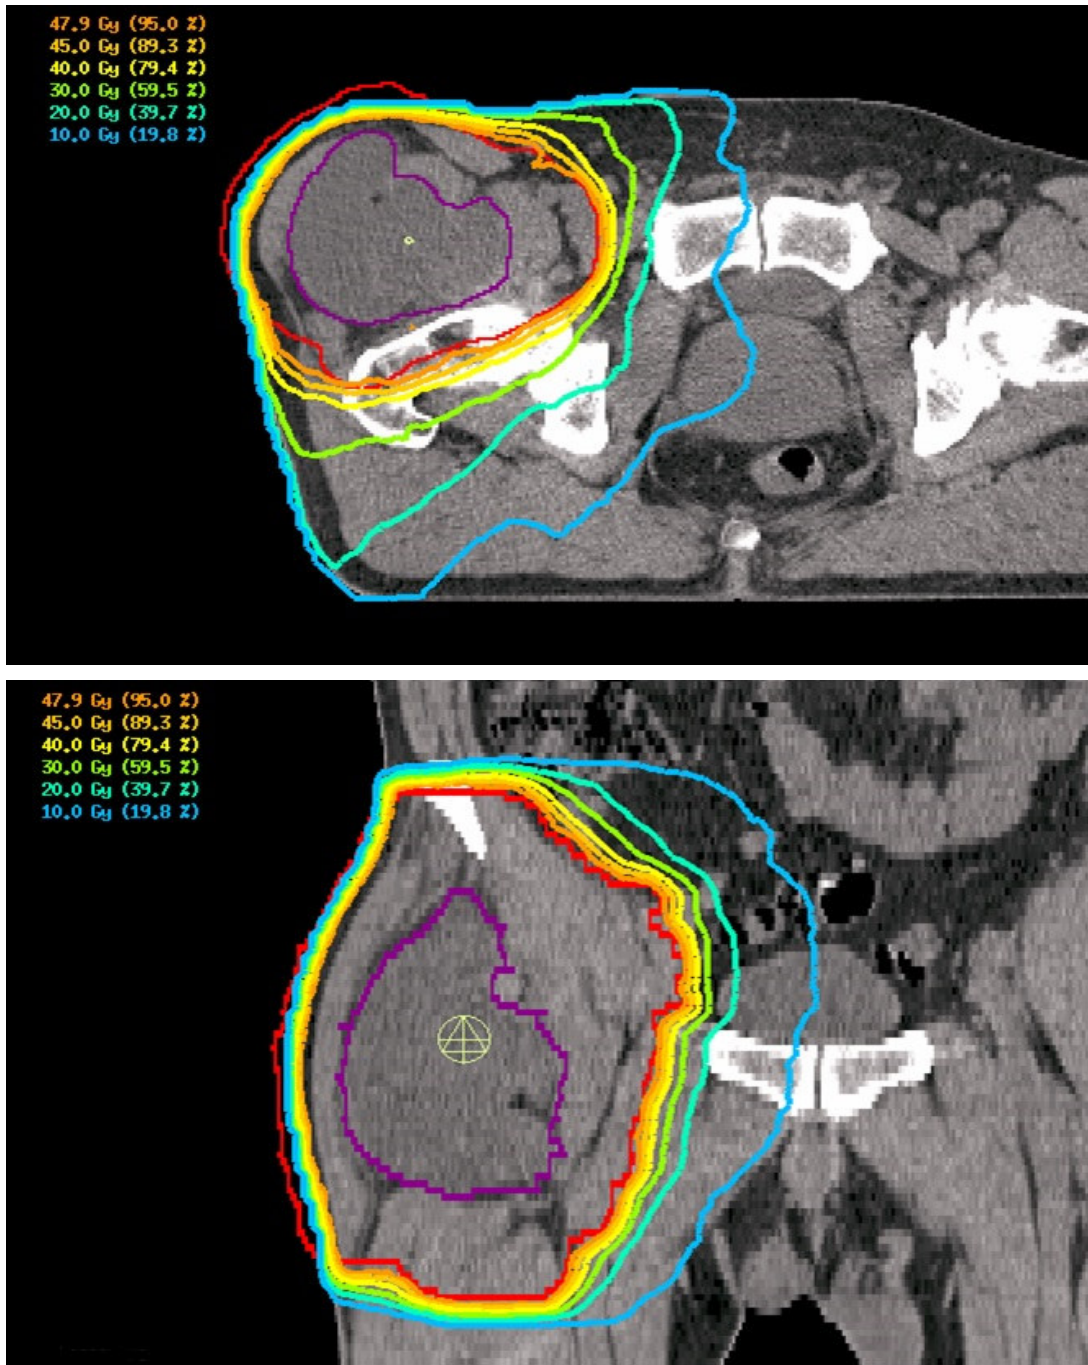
Radiation plan of a 68-years old male patient with myxoid liposarcoma, showing an isodose distribution of radiation therapy plan as well as gross tumor volume (violet) and planning target volume (red). The patient presented initially with an asymptomatic swelling of the lower right proximal extremity. MRI imaging showed a suspicious mass. The diagnosis of a myxoid liposarcoma was confirmed after biopsy. To complete the staging and exclude potential lung metastases, a CT scan of the lungs was performed. The case was presented in the multidisciplinary meeting, which recommended a multimodal preoperative treatment and wide surgical resection. The patient received a preoperative radiation therapy with 50.4 Gy in 28 fractions (1.8 Gy per fraction) with two cycles of concomitant intravenous Ifosfamide chemotherapy and concomitant hyperthermia twice a week (in total 10 treatments). En-Bloc resection was performed 6 weeks after the end of radiation therapy. Treatment was completed without relevant side-effects. Two years after the end of the treatment, no local recurrence and no distant metastasis were demonstrated in extremity-MRI and CT scan of the chest.
